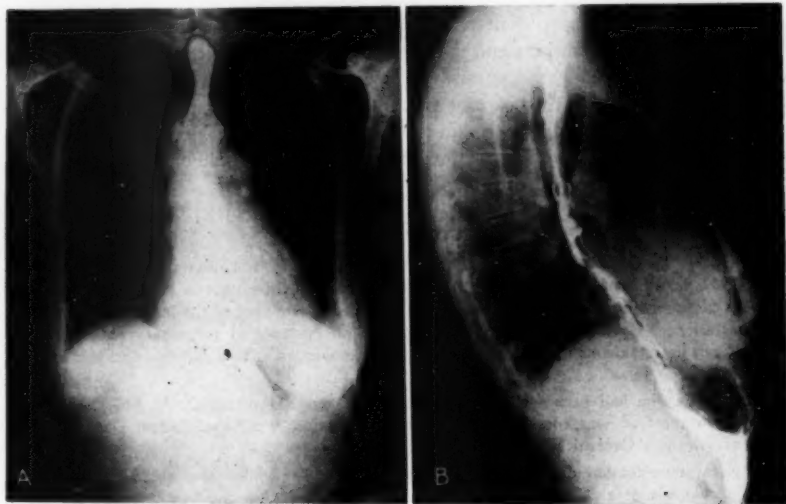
A*, posterior-anterior roentgenogram of the chest showing prominent pulmonary arteries and the tortuous course of the barium sulfate-filled esophagus. *B*, lateral view of the chest.
